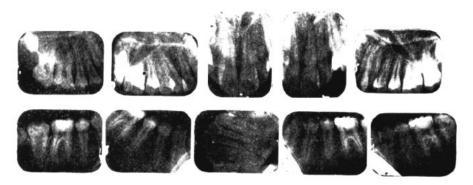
Radiographs before treatment.
